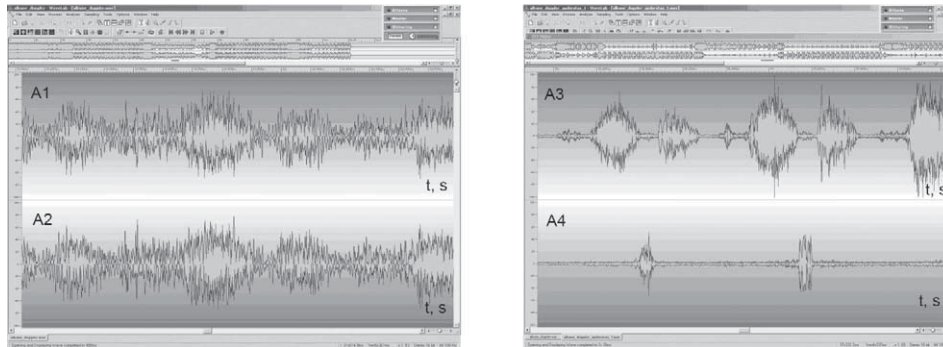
Signal after quadratic detector (a), direct and reverse Doppler signal are distinguished (b).
